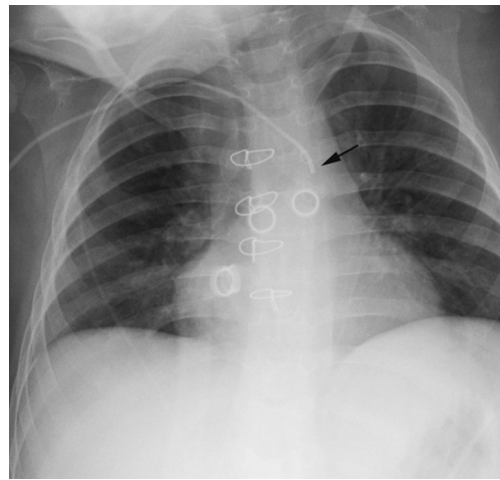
Case 1, a 32-month-old girl with heart failure and bilateral ventricular assist device. Anteroposterior chest radiograph shows an arterial catheter inserted via right subclavian approach with its tip in the ascending aorta (*arrow*), adjacent to the arterial cannula of the assist device
